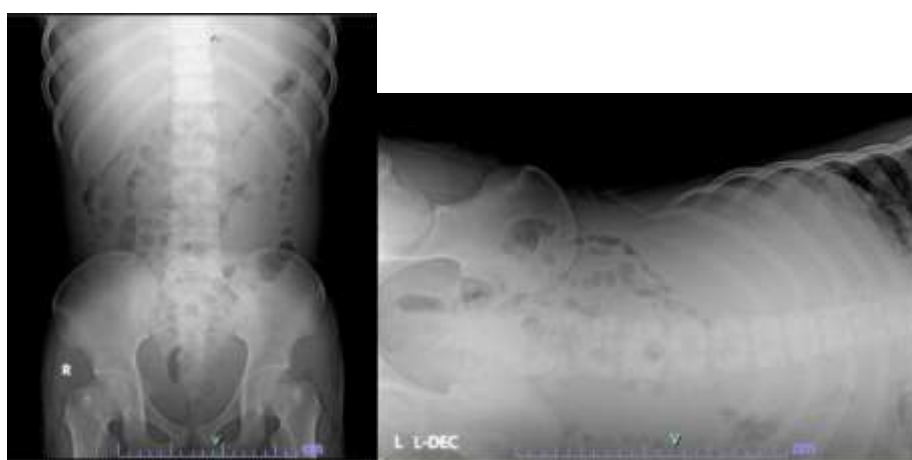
Abdominal x-ray consists of BOF (left) and LLD (right) showing abnormally distributed bowel gas
